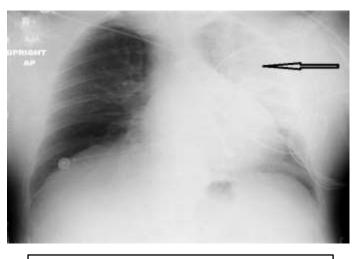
Xray of the chest revealed left upper lobe consolidation (arrow)
